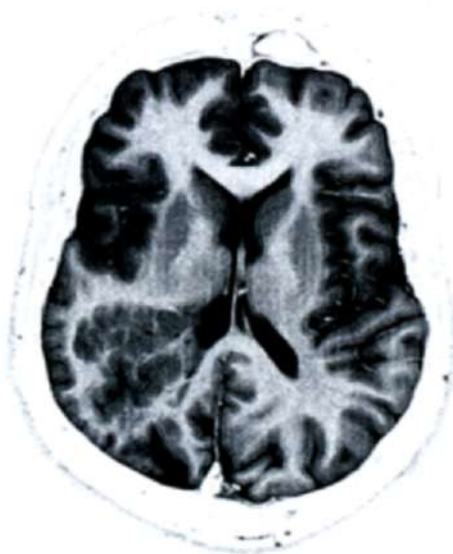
Axial MR image on inversion recovery displaying a collection of neuronal heterotopic nodules extending from the lateral ventricle to the subcortical white matter of the right parietal region. Note the abnormal gyration of the cortex overlying the malformation.
